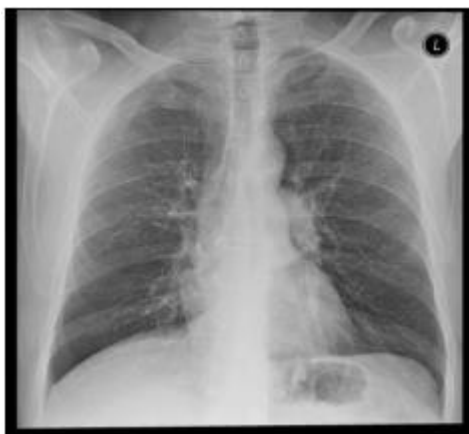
Lung Cancer X-Ray.
